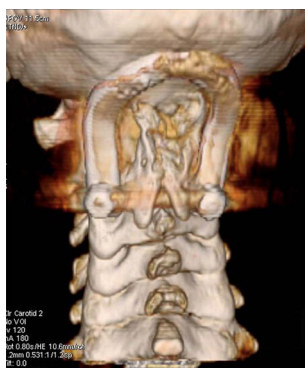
Computed tomography on a three-dimensional reconstruction view demonstrating a good fusion mass from the occipital bone to C2
